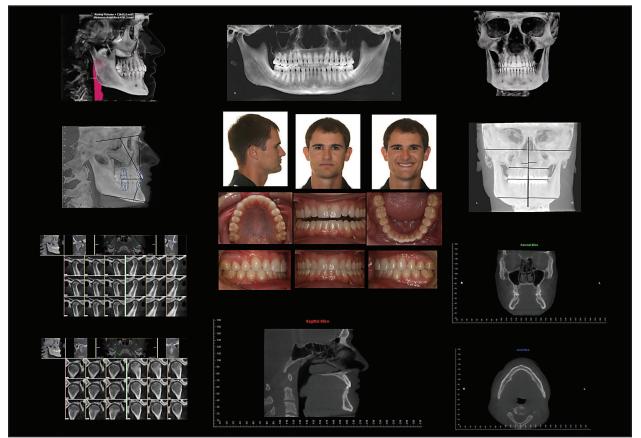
German Template of photographic and radiographic images used for diagnosis, progress checks, and distribution to other doctors.
